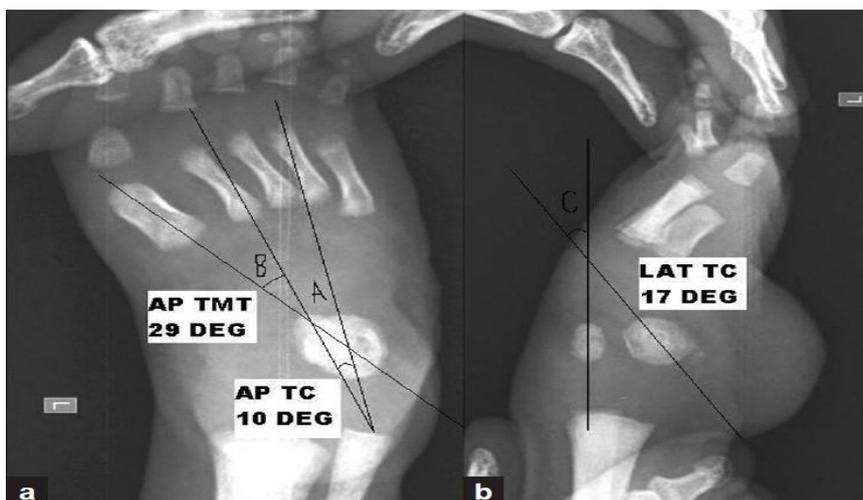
Anteroposterior (a) and lateral (b) radiographs of clubfoot<sup>8</sup>
